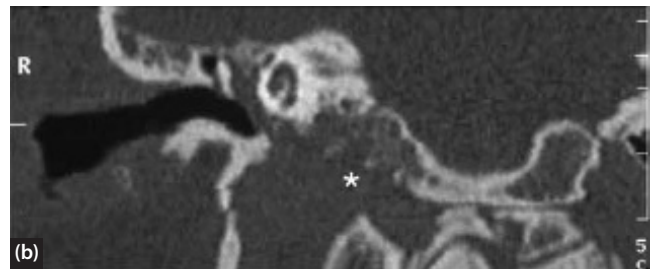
A 78-year-old man with a history of diabetes mellitus, polyneuropathy and chronic otitis media presented with right-sided facial palsy (House-Brackmann grade III) and signs of involvement of cranial nerves IX, X and XI. (a) Axial CT scan showing an irregular defect in the right petrous apex (asterisk) extending towards the jugular bulb. (b) The coronal plane (asterisk). (c) T2-weighted MRI; the right mastoid and some petrous apex cells are filled with fluid (arrows). (d) Scintigram (technetium-99m diphosphanate) with signal enhancement in the area of the right temporal bone. Diagnosis: jugular foramen syndrome as a result of petrositis/osteomyelitis of the skull base.
